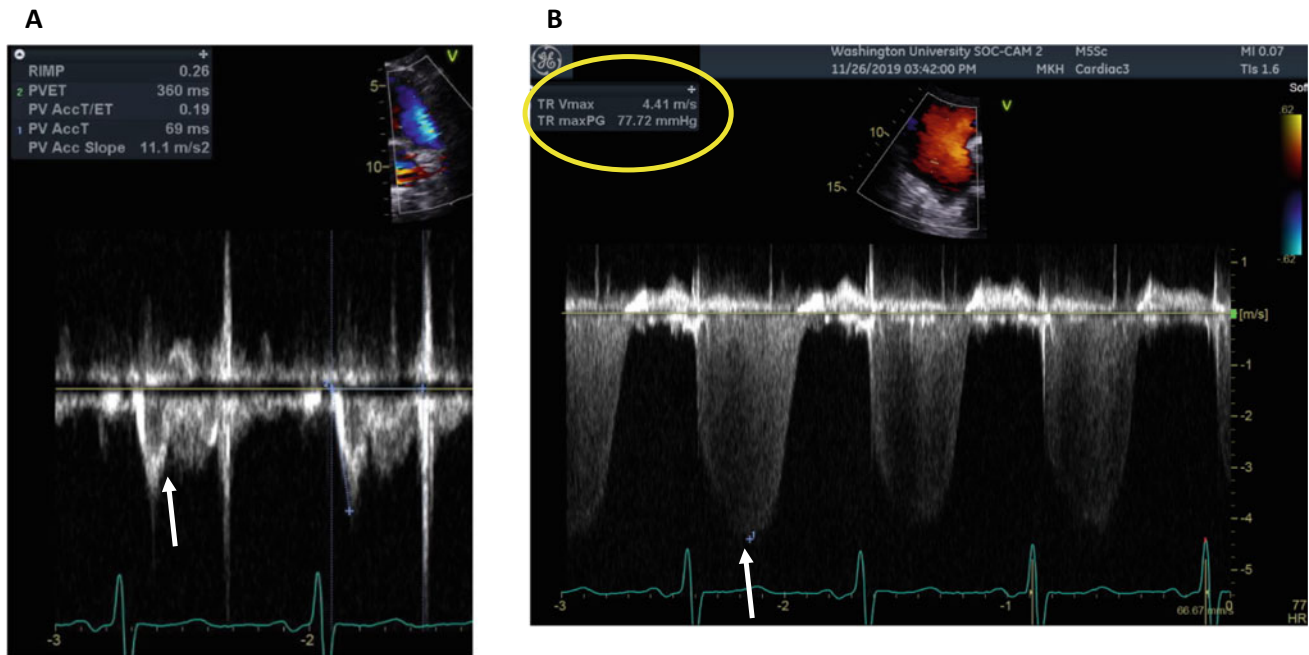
A Patient with multiple myeloma and new pulmonary hypertension. Pulsed wave Doppler across the right ventricular outflow tract demonstrates mid systolic notching (arrow) of the pulmonary arterial flow with markedly shortened acceleration time 69 ms
